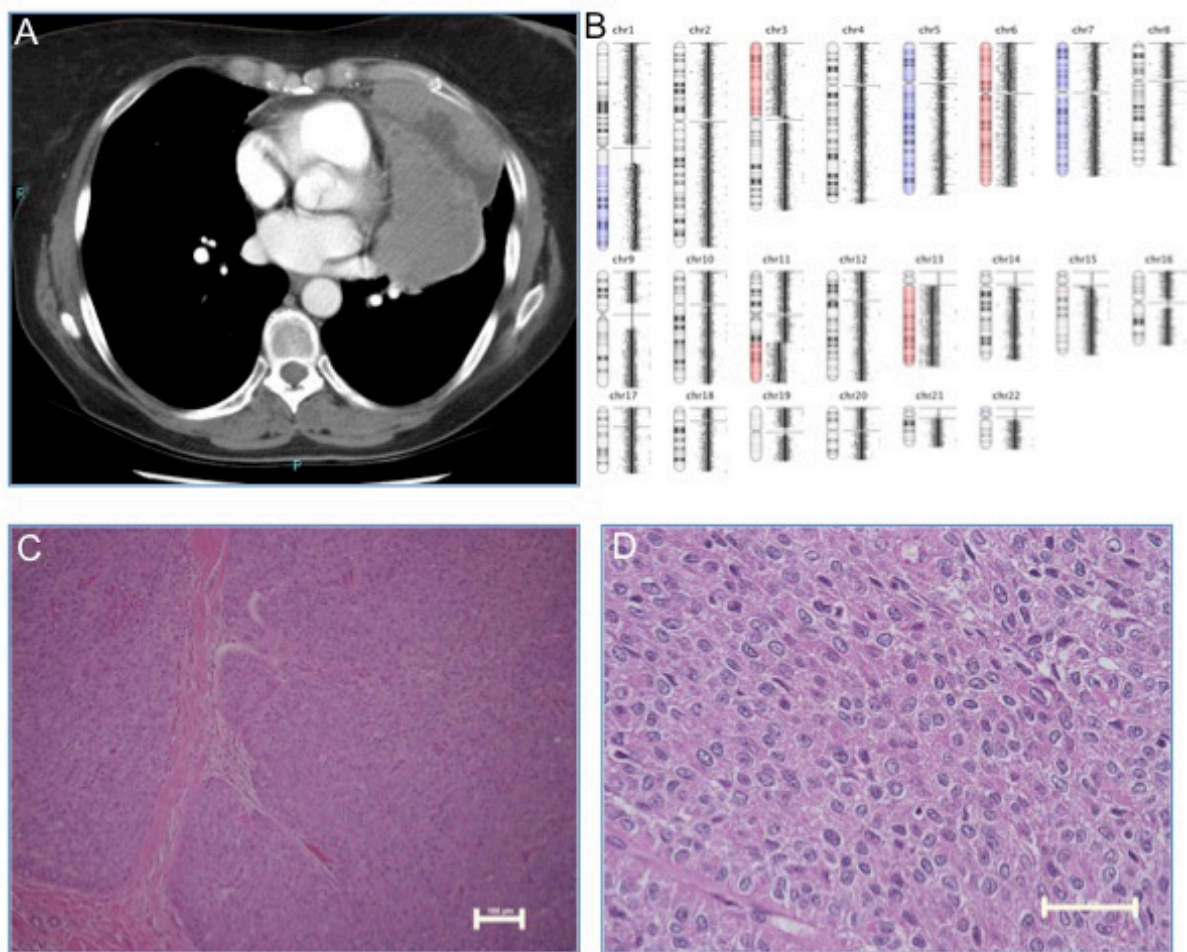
KSA tumor features. Panel A depicts the CT scan results performed before the surgical resection showing the cardiac root, the tumor occupying large part of the left hemithorax and invading the chest wall. (B) Summary of array CGH results for autosomal
